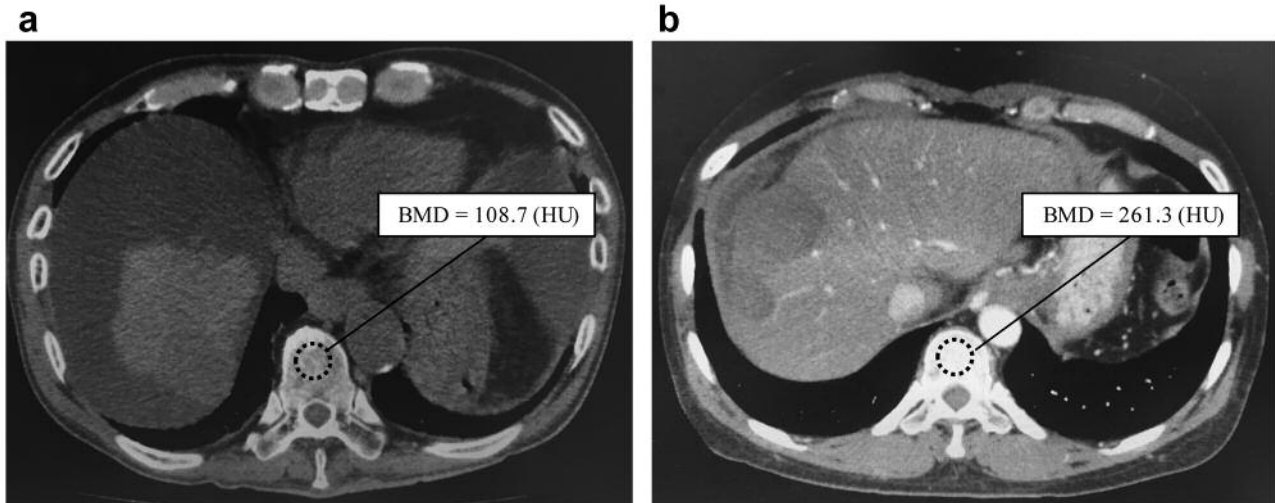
Two representative cases of osteopenia and non-osteopenia by computed tomography scans. (a) The measured BMD of the patient was 108.7 HU, which was lower than the calculated BMD by our formula of 147.3 HU. He had osteopenia and died 124 days after LDLT because of bacterial sepsis. (b) The measured BMD of the patient was 261.3 HU, which was higher than the calculated BMD by our formula of 168.0 HU. Although she had bacterial sepsis due to cholangitis after LDLT, she recovered and is alive more than 6 years after LDLT.
